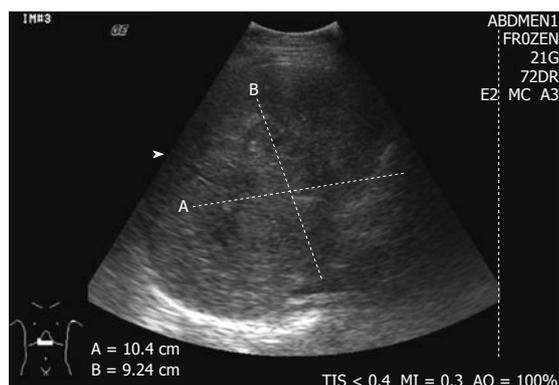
Ultrasound of liver showed mixed heterogeneous echogenicity lesions. Ill defined internal hyperechogenicity with "dirty shadow" appearance suspicious of gas content.
